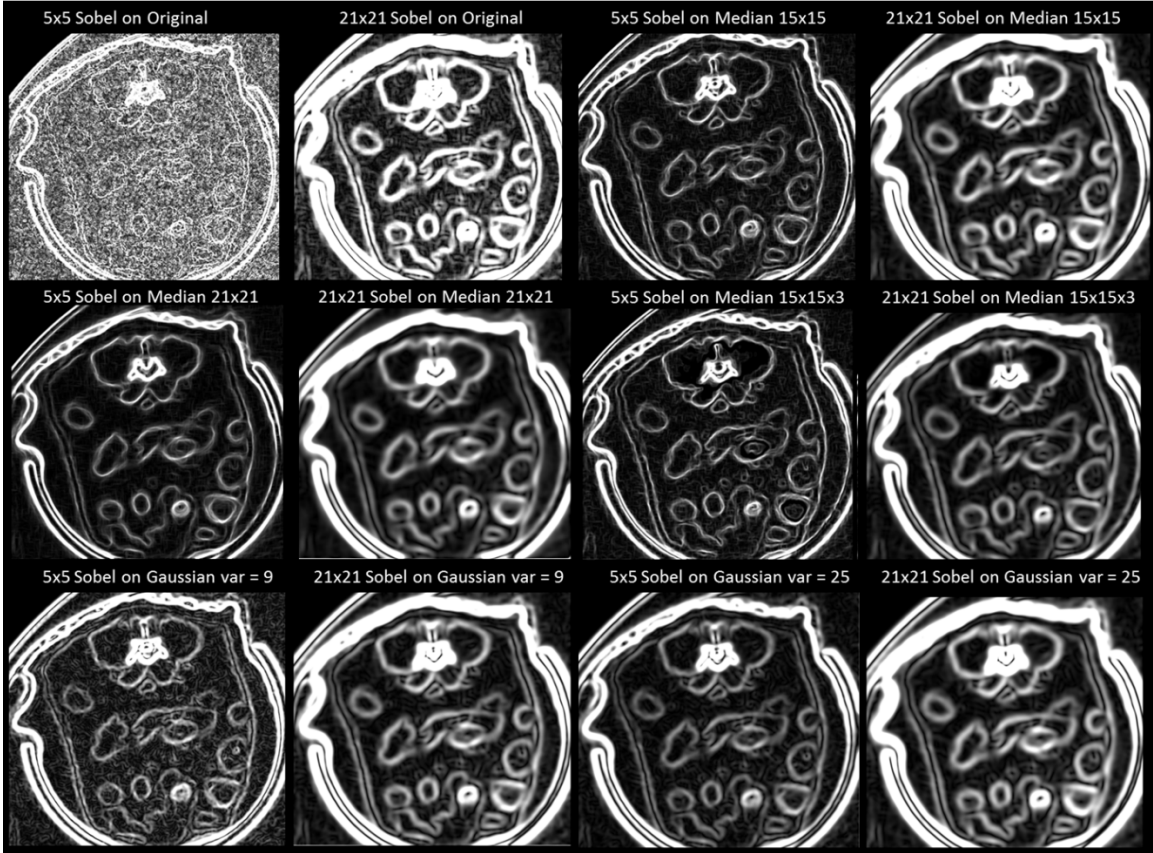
Sobel operator results using kernel sizes of 5x5 versus 21x21 on raw CT, 2D Median 15x15 and 21x21, 3D Median 15x15x3, and Gaussian smoothed volumes of variances 9 and 25.
